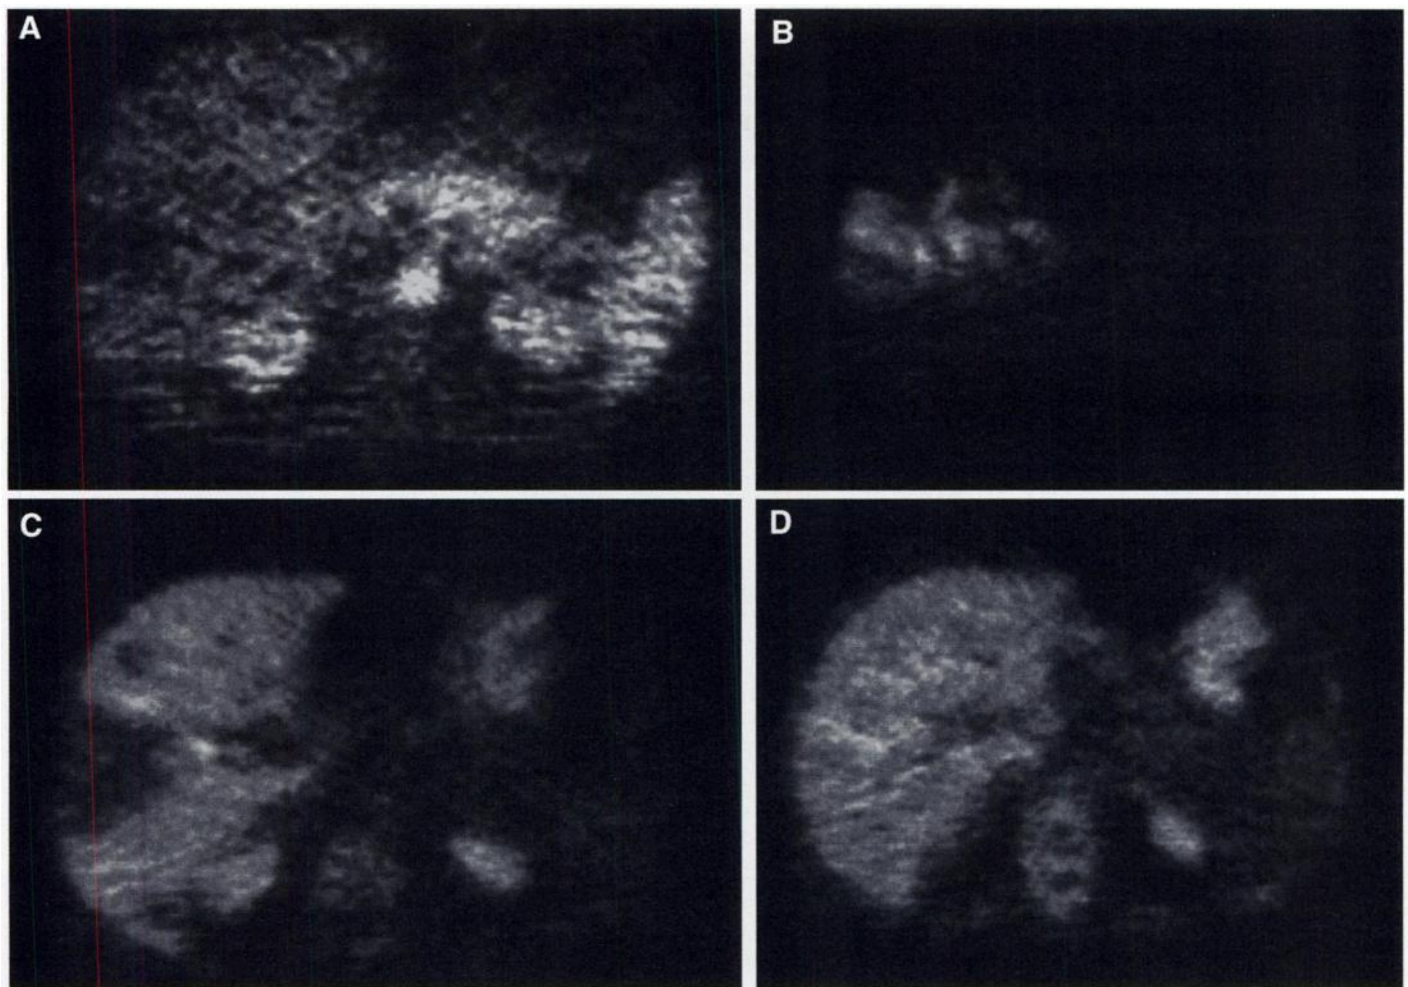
(A) PET cross-section 5 min after the intravenous application of ^{15}O -water in a patient with a liver metastasis from colorectal carcinoma in the lateral part of the right liver lobe. Decreased accumulation of the nonmetabolized tracer in the metastasis, in comparison to the normal liver parenchyma. (B) PET cross-section 1 min after the intra-arterial injection of ^{15}O -water in the patient in A. High, preferential accumulation of the nonmetabolized tracer in the metastasis in the lateral part of the right liver lobe, indicative of a better access and an enhanced perfusion of the lesion using the intra-arterial application. (C) PET cross-section 120 min after the intravenous application of ^{18}F -FU in the patient in A. The PET scan demonstrates a low accumulation of the labeled cytostatic agent in the metastasis in the lateral part of the right liver lobe, which is indicative of a low trapping of the tracer in the metastatic lesion. (D) PET cross-section 120 min after the intra-arterial application of ^{18}F -FU. The PET scan demonstrates nearly homogeneous distribution of the tracer in the metastasis, which cannot be delineated from the normal liver parenchyma. The intra-arterial application resulted in significantly higher ^{18}F -FU trapping. (E) Spline interpolated ^{18}F -FU time-activity data expressed in SUV for the metastasis and the normal liver parenchyma following intra-arterial as well as intravenous administration of the tracer. The intra-arterial infusion resulted in significantly higher ^{18}F -FU uptake values in the metastasis during the entire acquisition time.
